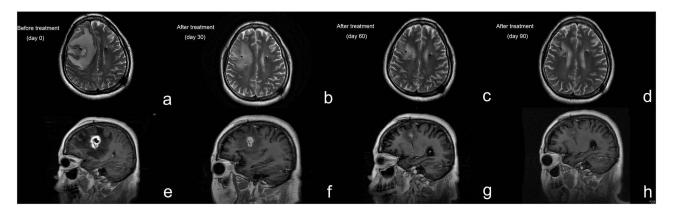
Panels (a–d) present T2 propeller images captured from August 18, 2023, to November 17, 2023, panels (e–h) display T1-weighted images with contrast enhancement (T1+C).
